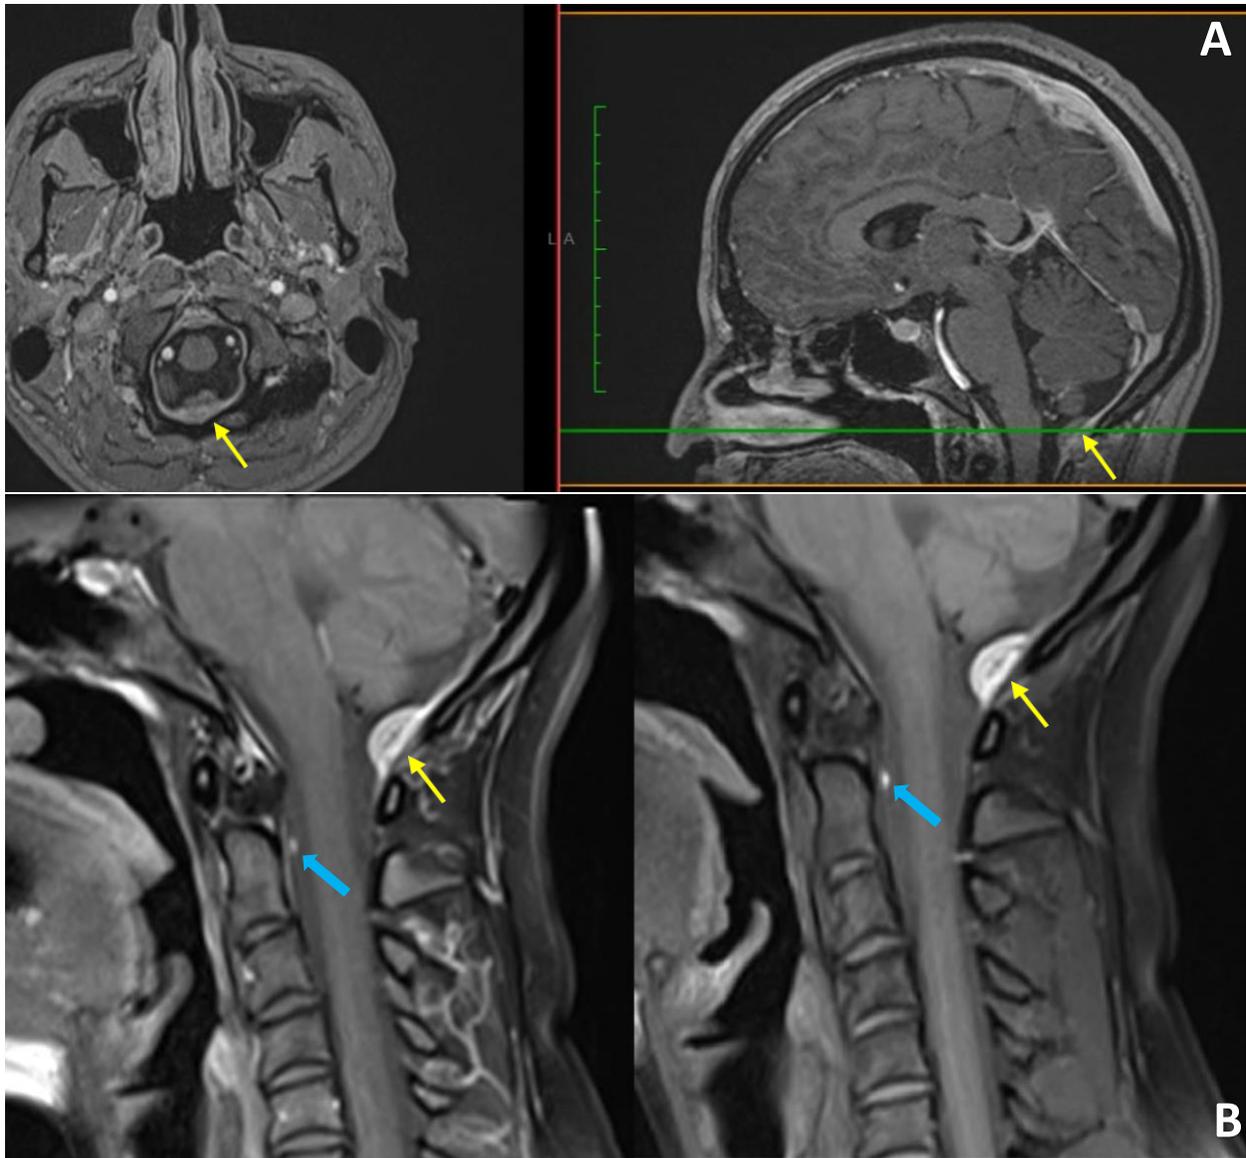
(A) The third brain MRI of June 2025 in American Hospital 3, showing the lesion in T1 gadolinium ISO- sequence, in axial and sagittal view (yellow arrow)
